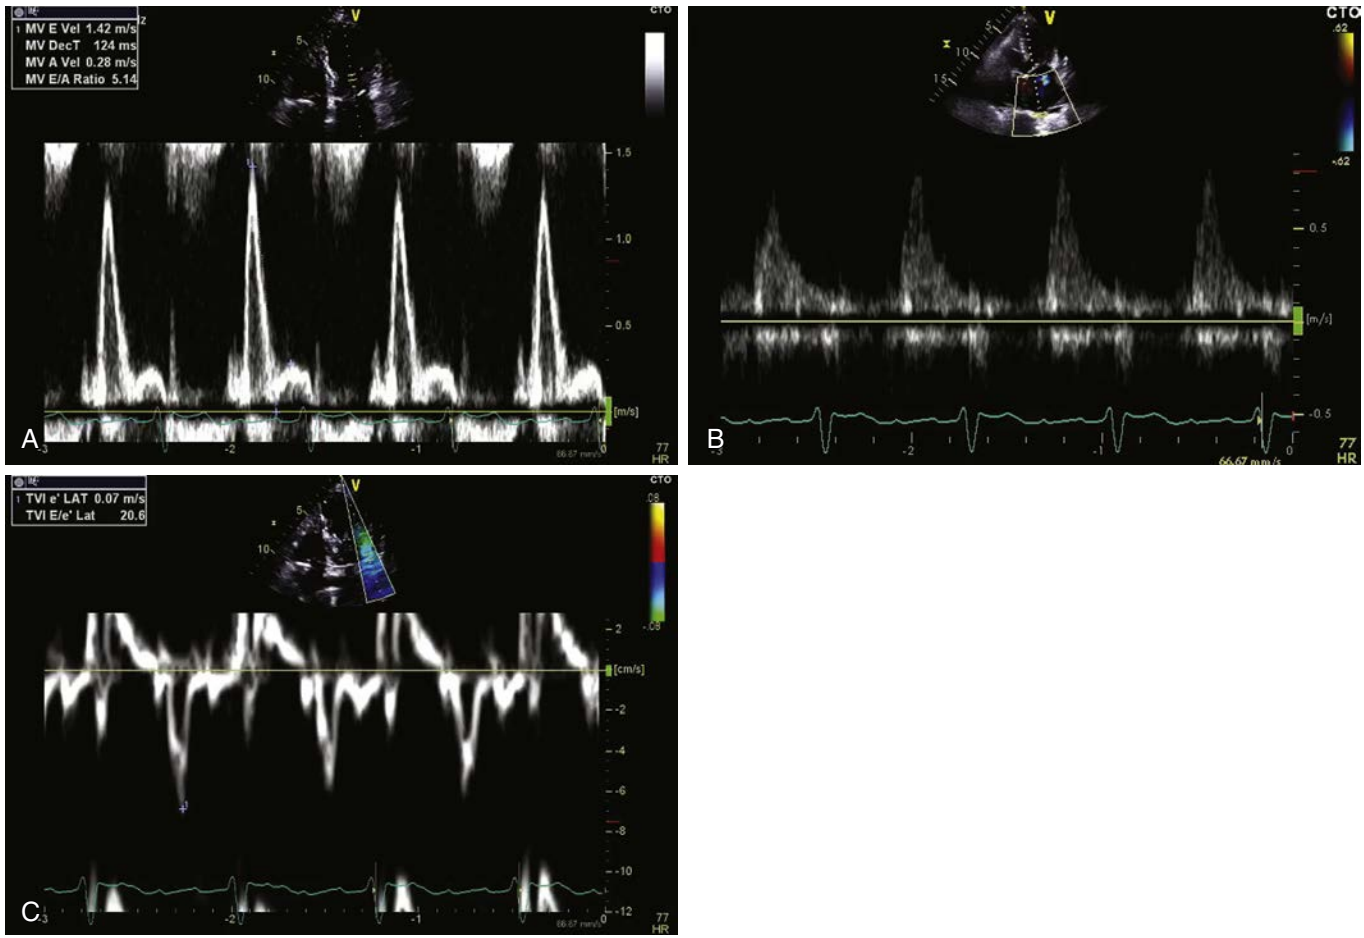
Severe left ventricular (LV) diastolic dysfunction after myocardial infarction (MI). Restrictive LV filling after MI demonstrated by pulsed-wave Doppler interrogation of the transmittal flow (A) and pulmonary venous flow (B), and by tissue Doppler imaging of the lateral mitral annulus (C). A, Peak late diastolic transmittal flow velocity; A_m , peak late diastolic mitral annulus velocity; D , peak diastolic pulmonary venous flow velocity; $DecT$, deceleration time; E_m , peak early diastolic mitral annulus velocity; MAV , mitral annulus velocity; MV , mitral valve; S , peak systolic velocity; S_m , systolic MAV ; TVI , time velocity integral.
